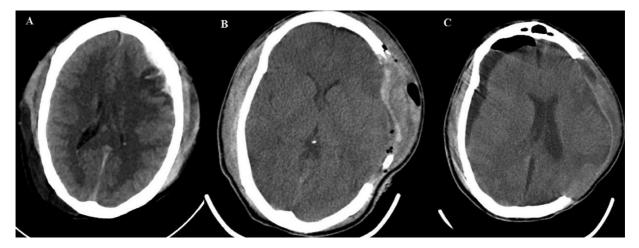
Contralateral subdural hygroma. Noncontrast CT head showing (A) left frontoparietal acute SDH with a midline shift of 5 mm with bilateral frontotemporoparietal sulcal SAH. (B) Left FTP DC. (C) Contralateral frontoparietal subdural hygroma.
